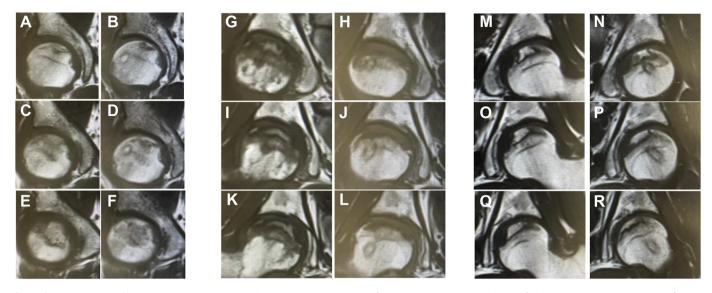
Change in necrotic volume on magnetic resonance imaging. A–C: Preoperative image of patient 1. B–F: Postoperative image of patient 1. G–K: Preoperative image of patient 2 (right hip). H–I: Postoperative image of patient 2 (left hip). N–R: Postoperative of patient 2 (left hip).
